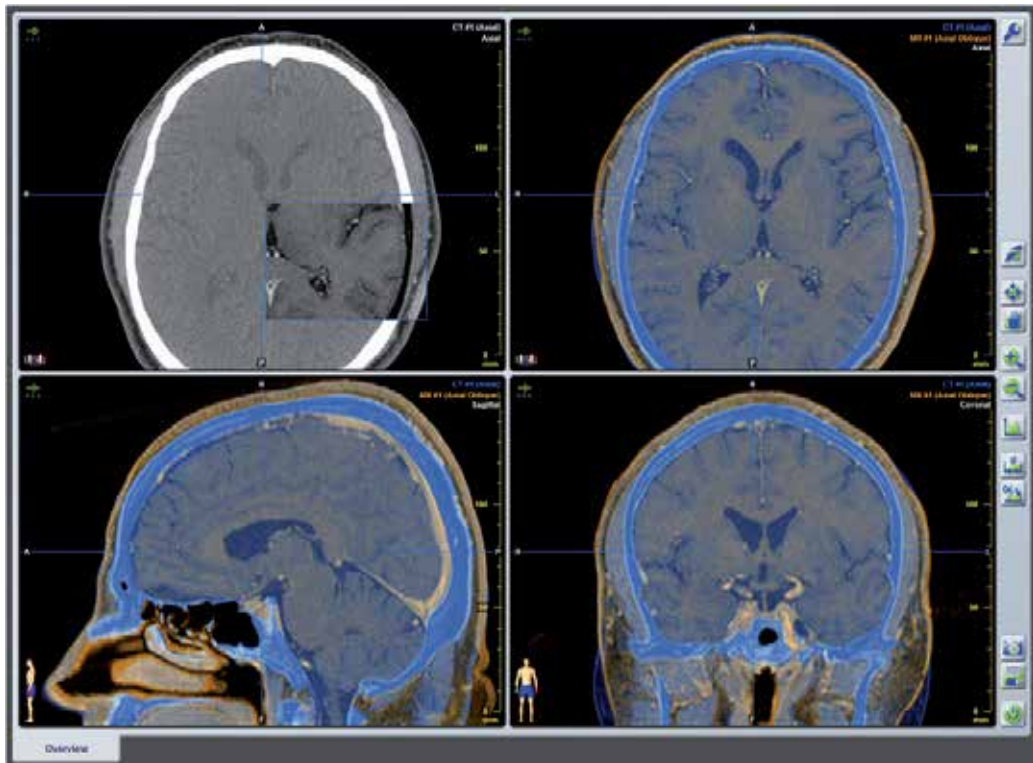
CT/MRI fusion on Workstation
